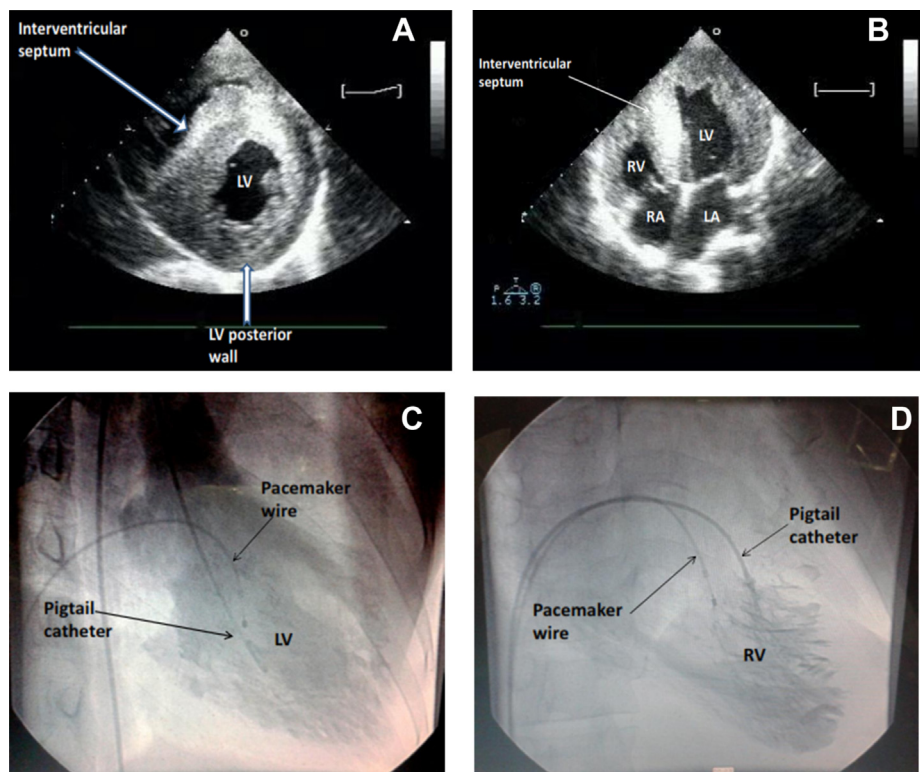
Two dimensional echocardiography in short axis (A) and apical 4 chamber view (B) shows speckled appearance and thickening of interventricular septum, LV and RV posterior wall. LV angiogram (C) and RV angiogram (D) showing hypertrophied ventricles. LA – left atrium, RA – right atrium, LV – left ventricle, RV – right ventricle.
